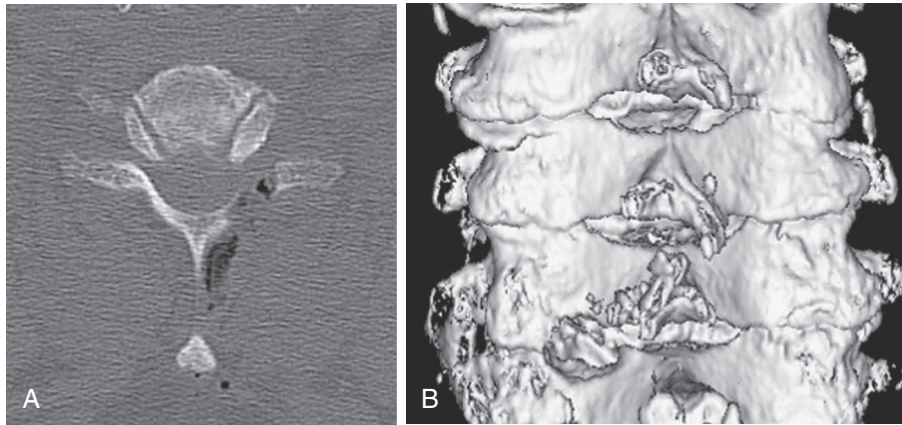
A, Postoperative CT showing a foraminotomy at C6-7. B, Three-dimensional reconstructed image of the foraminotomy.
